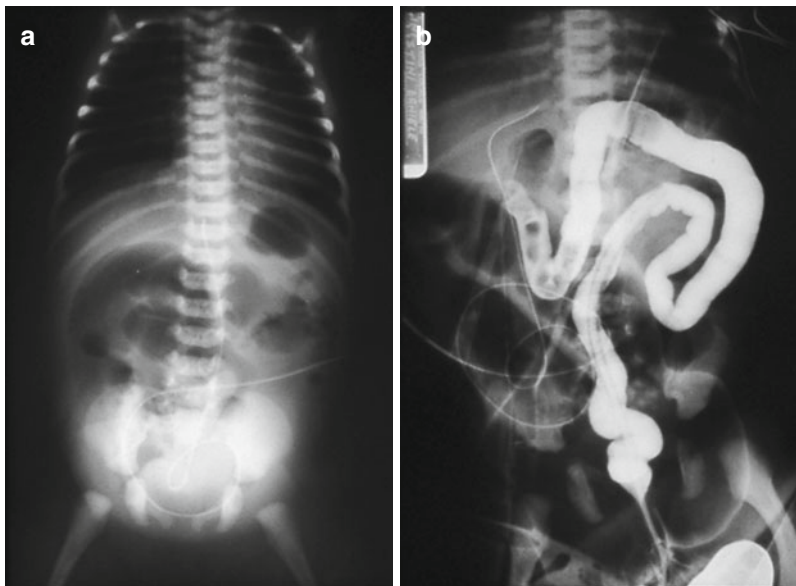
(a, b) Plain film (a) and enema (b) in infant with meconium ileus; note the proximal distended loops at the plain film with no air in the lower abdomen. The enema shows typical filling defect in the colonic tract
